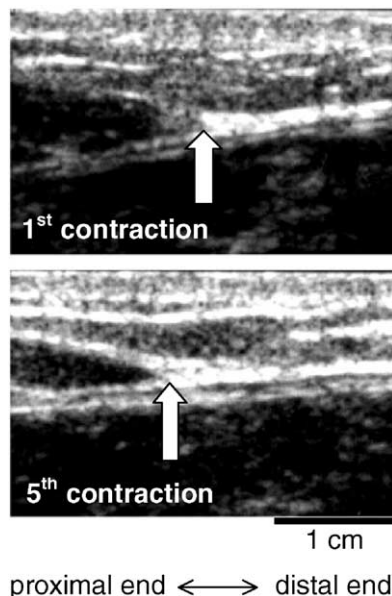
Typical sonographs over the GS muscle–tendon unit in the first and fifth electrically stimulated contractions in one subject. The arrows point to the GS tendon origin. Both scans were taken at a plantarflexion moment of 82 Nm.
